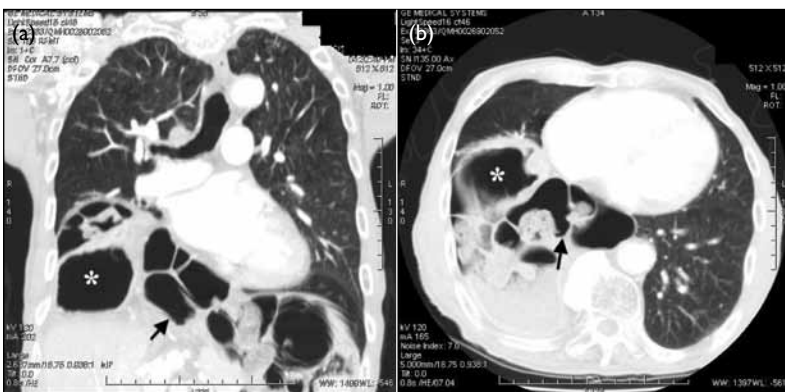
Thoracic computed tomography with contrast: (a) coronal reformatting and (b) axial view. These show the stomach (*) and transverse colon (→) within the right hemithorax
